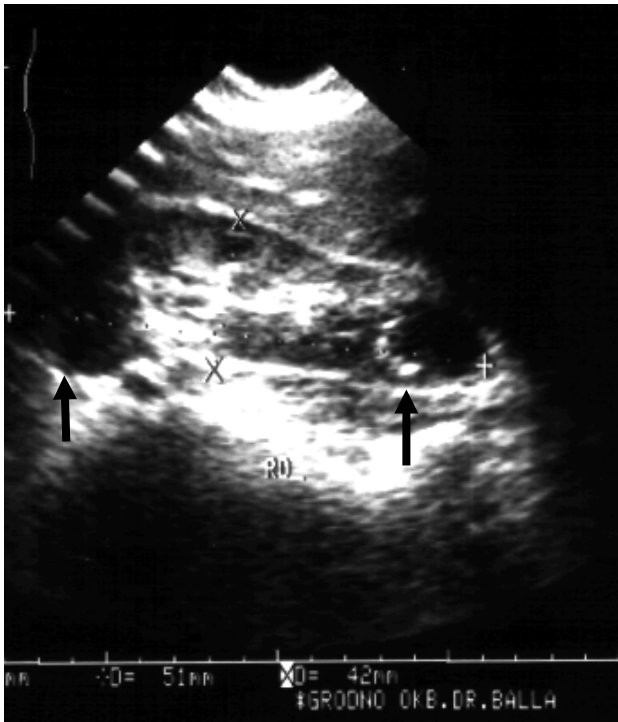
Abscess of kidney. Sonogram along a long axis of right kidney. Abscess of kidney as hypoechoic zones with indistinct contours (arrows)
